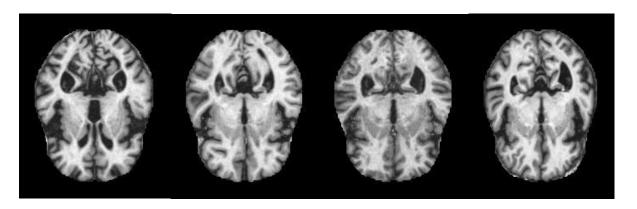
MRI DATASET (USC, n.d.)
